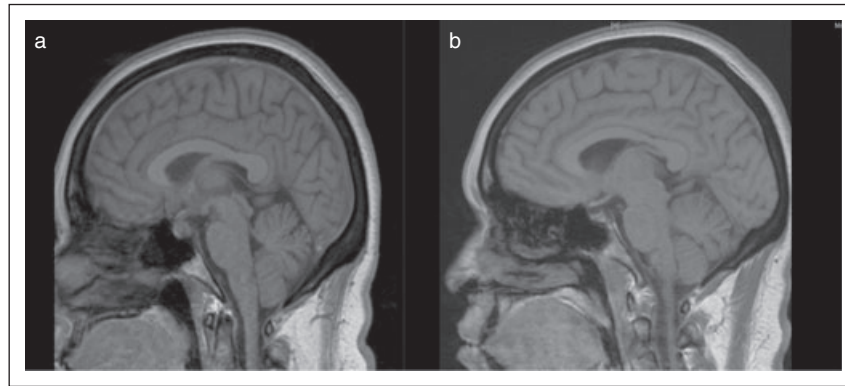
(a) MRI prior to surgery showing the pituitary mass lesion. (b) MRI following surgery. MRI = magnetic resonance imaging.
